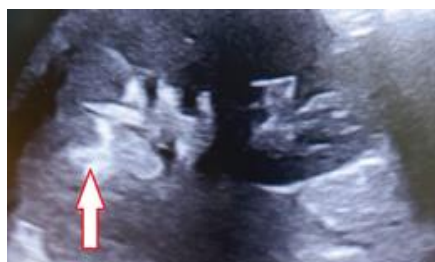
Intraoperative ultrasound shows the residual stone in the upper calyx of the right kidney for the same above patient in figure No 1
